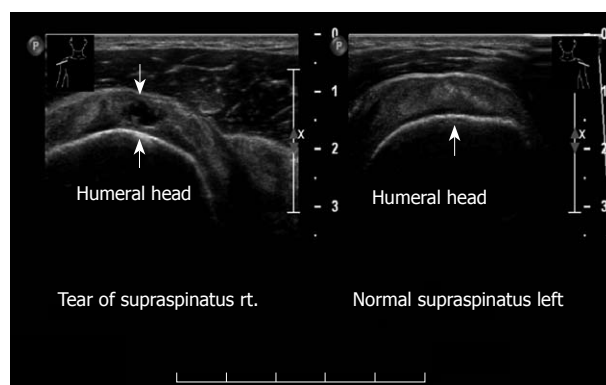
Transverse sonogram, supraspinatus right and left shoulder. Anechoic defect. Partial thickness tear, right. Left: Normal supraspinatus.
